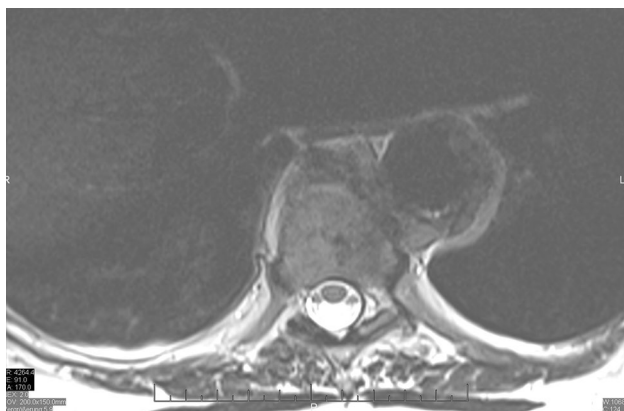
The tumor, preoperative (CT scan with contrast medium, transversal plane)
